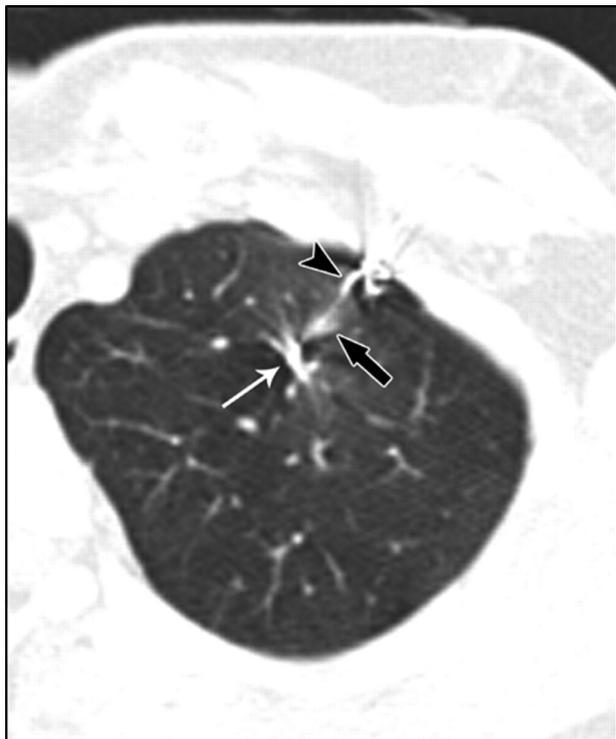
Nonenhanced transverse chest CT scan shows complete ejection of the microcoil from the Chiba needle and successful localization of a nodule at the left lung apex (black arrow). The deep end of the microcoil is coiled into a ball adjacent to the nodule (white arrow) and the superficial end is coiled on the visceral pleural surface. No hemorrhage is noted in the normal lung tissue adjacent to the wire (arrow head). CT, computed tomography.
